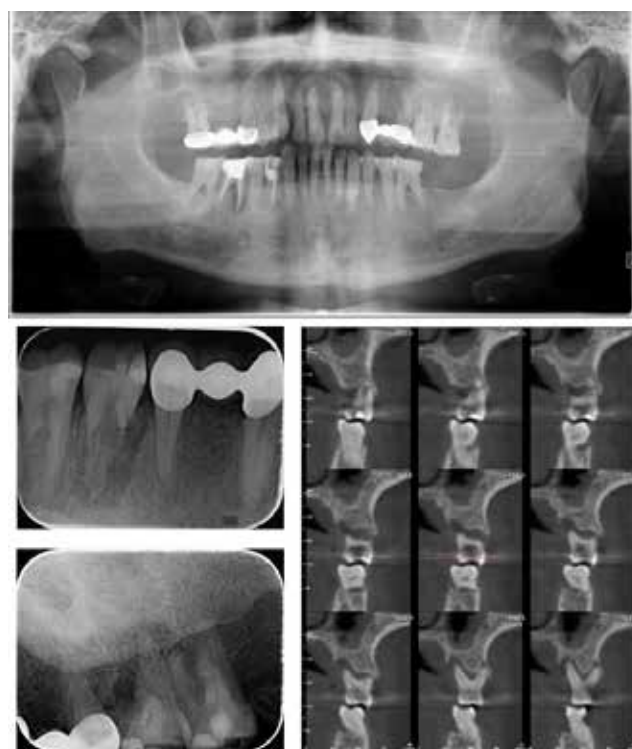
Panoramic X-ray, periapical radiography and CBCT
